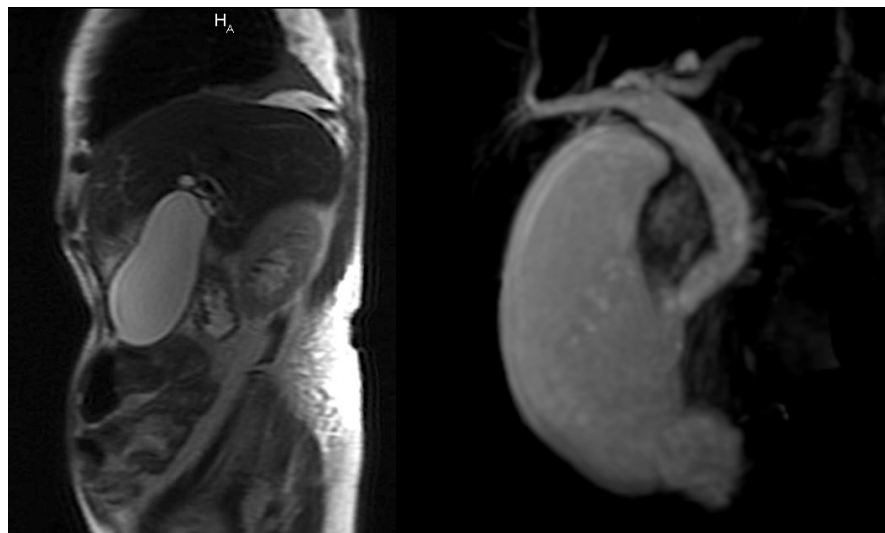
Magnetic resonance imaging demonstrating extrinsic compression of duodenum by a dilated gallbladder. Common bile duct without alterations.
